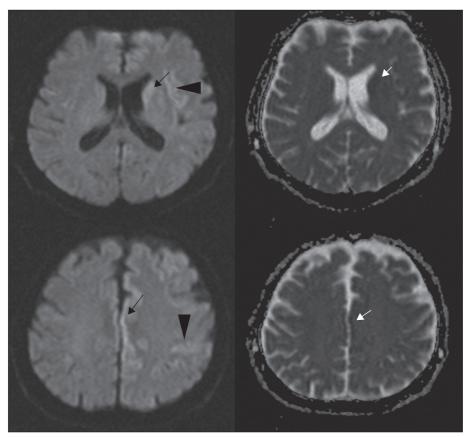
Brain MRI demonstrates restricted diffusion in bilateral caudate nuclei, predominantly on the left side; on the left frontal, temporal, and parietal cortical gyri, involving the primary motor area and insular cortex, as evidenced by diffusion-weighted imaging hyperintensity and ADC hypointensity. Arrows indicate caudate nucleus and cortical gyri; arrow-heads indicate insular cortex and primary motor area.
